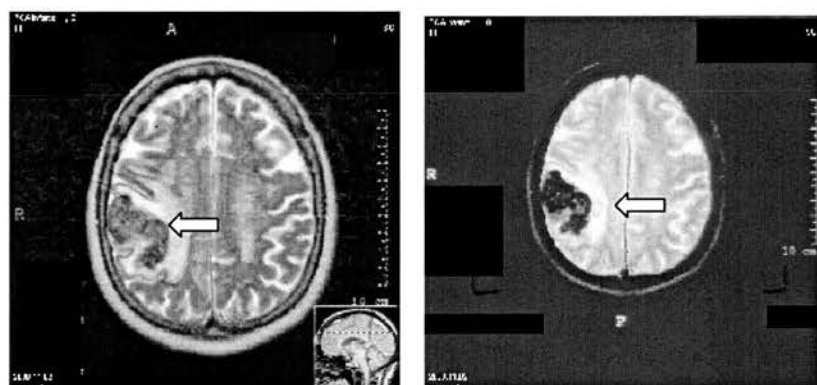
Haemorrhage on MRI. Left picture: T2 sequence – area of relative hypointensity right parietal region (arrow). Right picture: gradient echo sequence – note more marked hypointensity in affected region (arrow)
